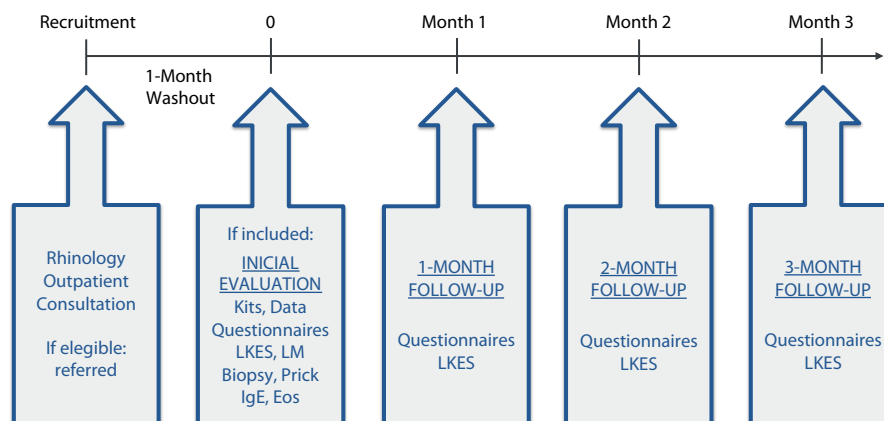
Timeline. LKES = Lund-Kennedy Endoscopic Score; LM = Lund-Mackay Computed Tomography Score; Prick = Skin prick test; IgE = Total immunoglobulin E; Eos = Serum eosinophilia.
